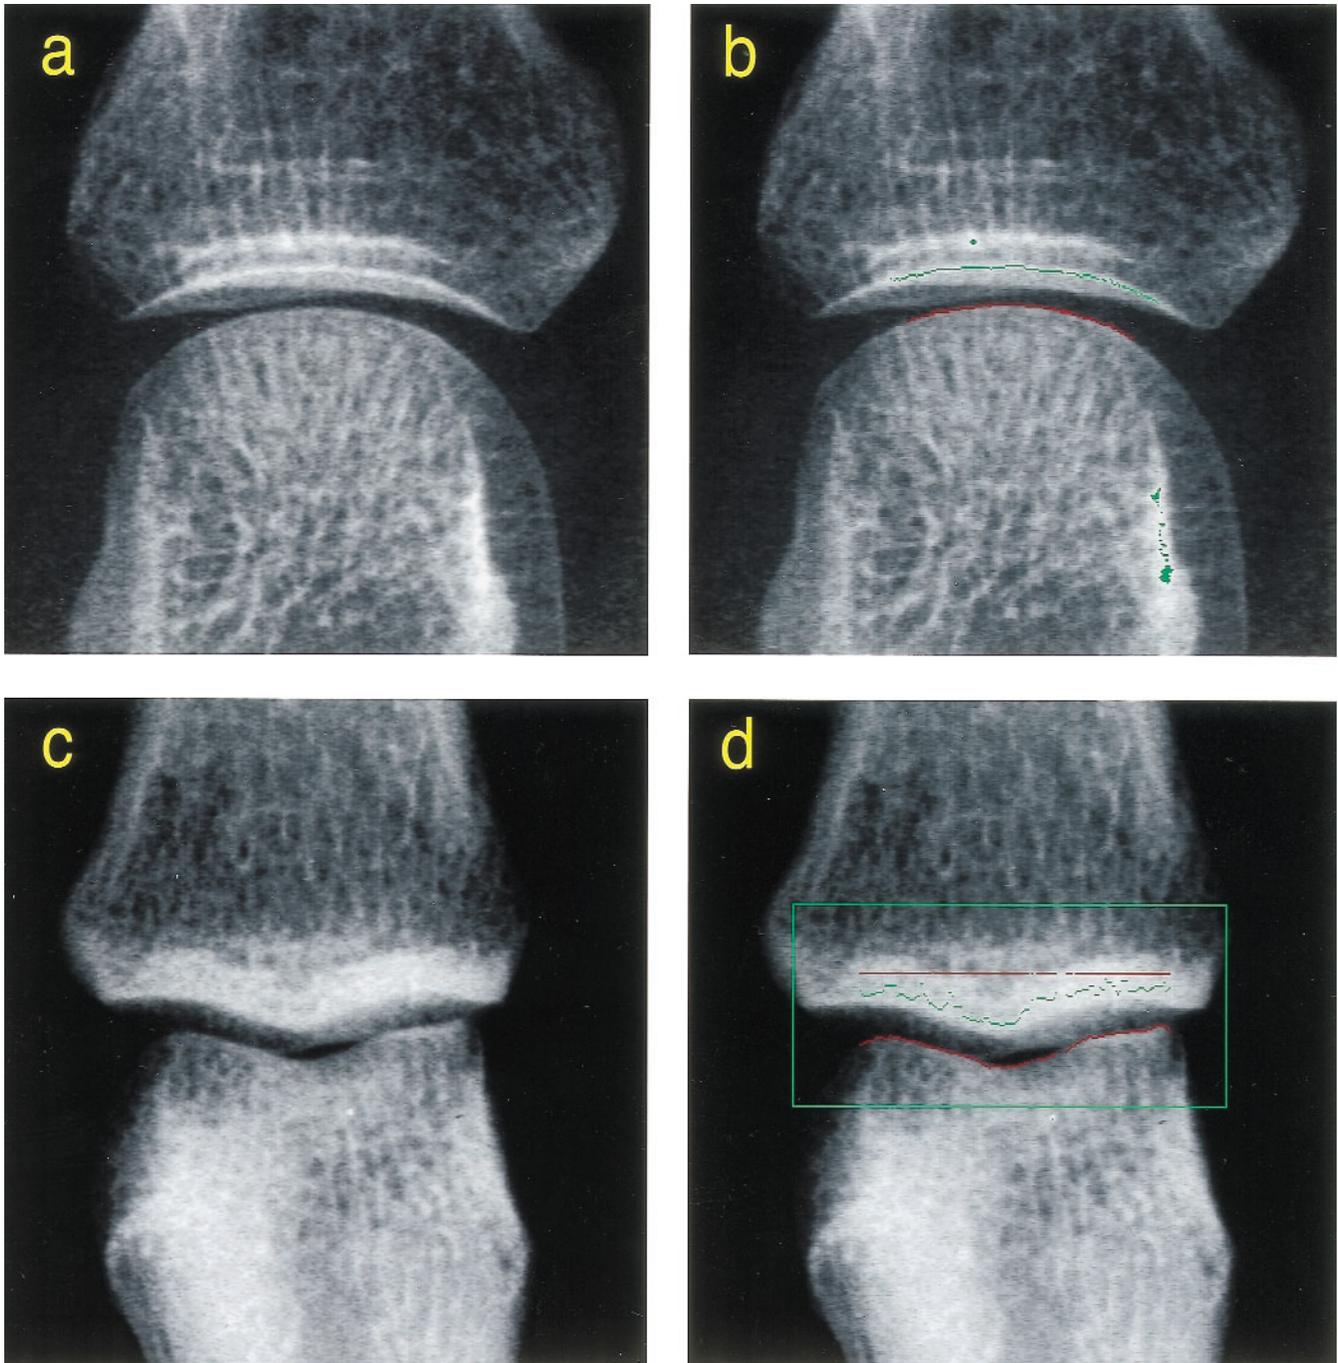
The effect of anatomical variation on the landmarks used for the computerized mean JSW measurement in MCP and PIP radiographs: (A, C) unprocessed radiographs; (B, D) processed images showing detection of the proximal (red) and distal (green) joint margins. In comparison with Figure 2, where the joint margins are unambiguous, in (A) a parallel range of subchondral compacted bone lies adjacent to the MCP distal margin, whereas in (C) the PIP distal margin is thickened. In (B) certain pixels distant from the margin are colored green, indicating that they are at the brightest level of the image intensity scale. These points have not been identified as lying on the joint margin. The rectangular box in (D) is input by the user to roughly locate the PIP joint. The horizontal red line corresponds to accepted valid measurements across the PIP joint.
